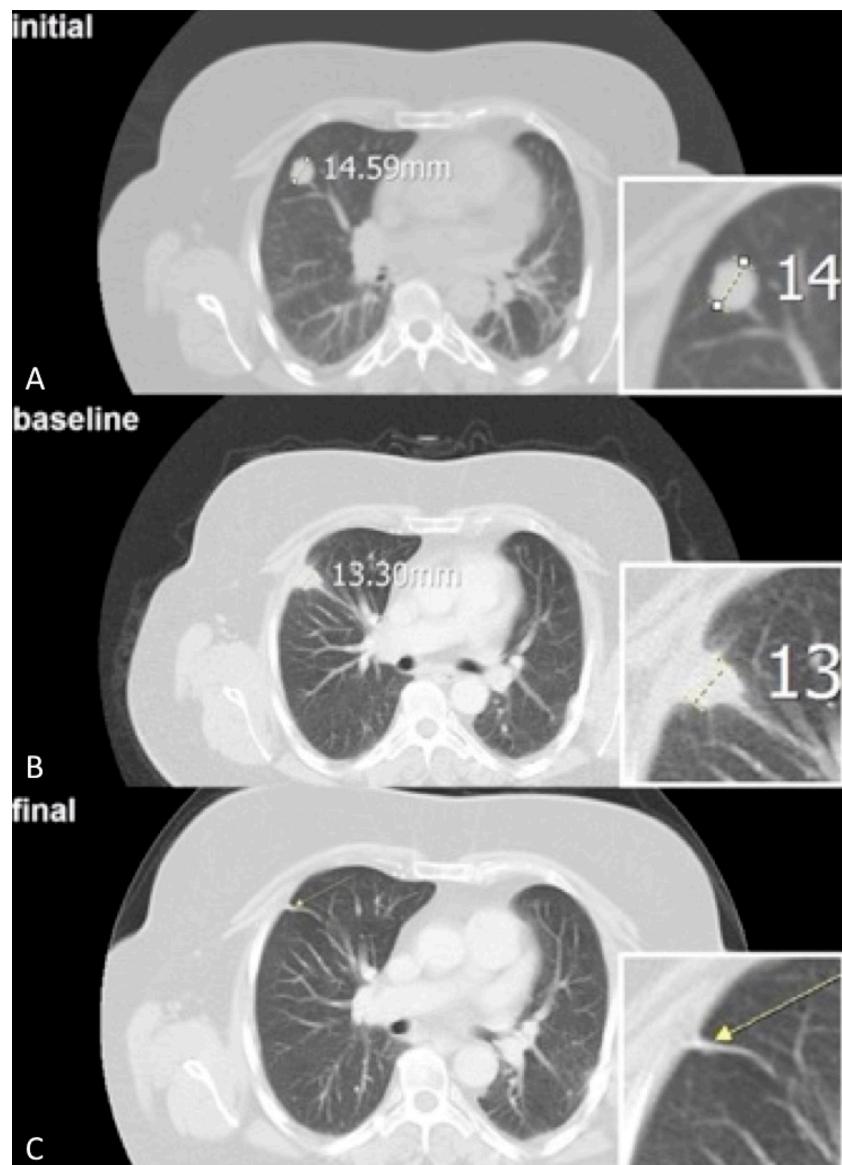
(A) The axial initial CT scan of the right lung shows a 1.5 cm large tumor of a patient with a colorectal cancer metastasis. (B) After the CT-guided radiofrequency ablation (RFA) of the pulmonary lesion, the baseline CT scan shows a typical surrounding pleural reaction. (C) Complete remission (CR) after a follow-up period of 25 months.
